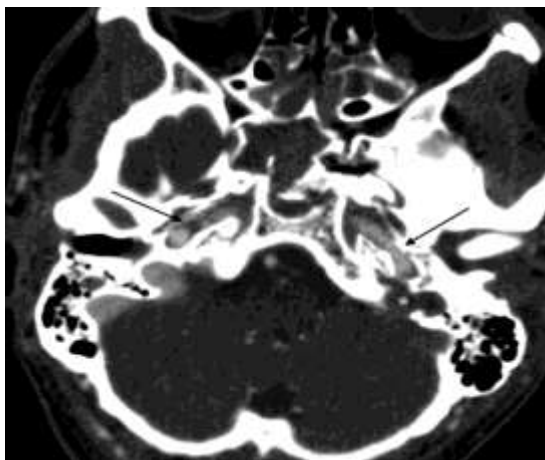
Post-traumatic internal carotid artery impairment; CT angiography (CTA) in a patient with multiple facial skeleton and skull base fractures following a severe head trauma. Both ICA canals are impaired with inhomogeneous intravascular enhancement and abnormal vessel contour of both ICAs (arrows). A brain MRI scan performed a few hours later revealed typical watershed territory stroke signs. Note the filling defect of the left jugular gulf (asterisk) as indirect sign of a post-traumatic traumatic dural venous sinus thrombosis (see Figure 36).
